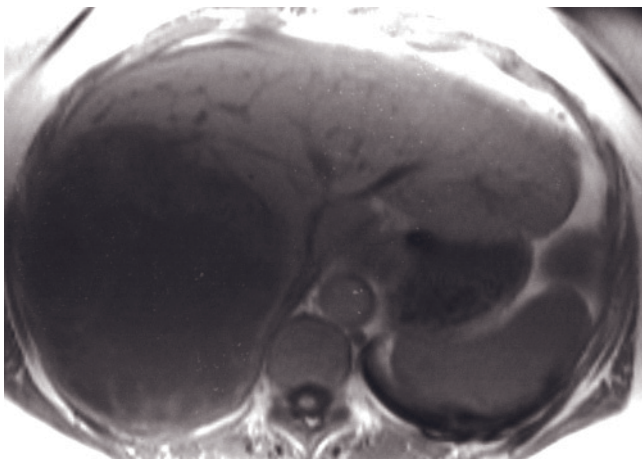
Angiosarcoma. Fat-suppressed T2-weighted ETSE (a) and 90-s (b) and 10-min (c) postgadolinium SGE images. A 2-cm angiosarcoma is present in the right lobe of the liver. The mass is well defined and largely hyperintense on the T2-weighted image (arrow, a) with a central region of low signal intensity due to hemorrhage. On the 90-s postgadolinium image (b), peripheral nodular enhancement is present. By 10 min after contrast (c), nodular enhancement has progressed centripetally, with a central nonenhanced area that corresponds to the region of hemorrhage on the T2-weighted image. Angiosarcomas mimic the appearance of hemangiomas. The presence of hemorrhage in this case is a common finding in angiosarcomas and rare in hemangiomas. Interval increase in size of this tumor is identified on a follow-up study obtained 1 month later, shown on fat-suppressed T2-weighted SS-ETSE image (d). Increase in size of a second tumor is also present. Rapid growth is compatible with angiosarcomas and not with hemangiomas. A change in the signal intensity of the larger mass on the T2-weighted image (d) is also noted between studies because of aging of the central hemorrhage.
